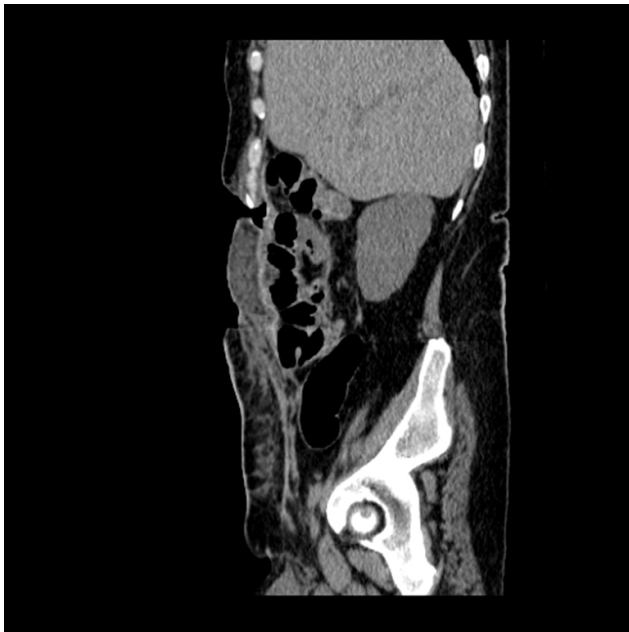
Sagittal CT scan before the third intervention
